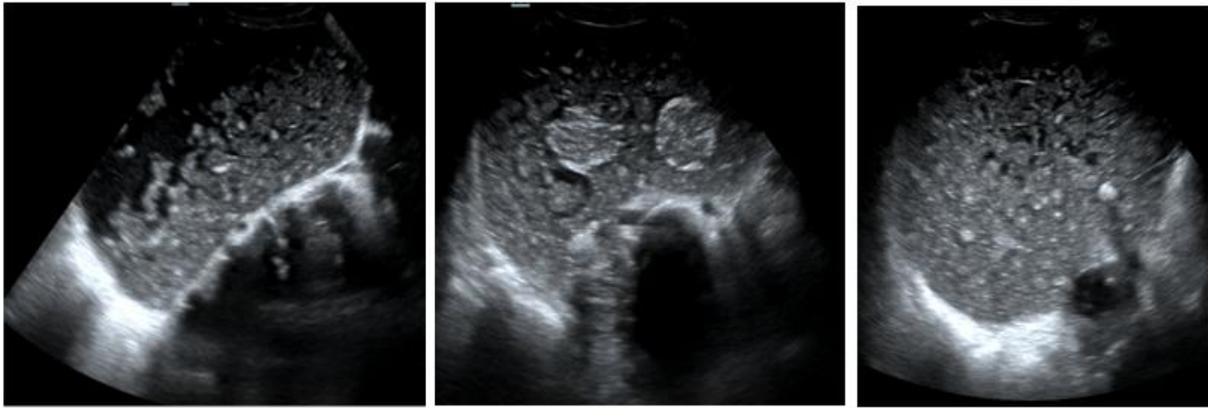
Sonogram shows a cystic mass containing multiple floating spherical hyperechoic globules, variable diameter, with some hyperechoic dots
